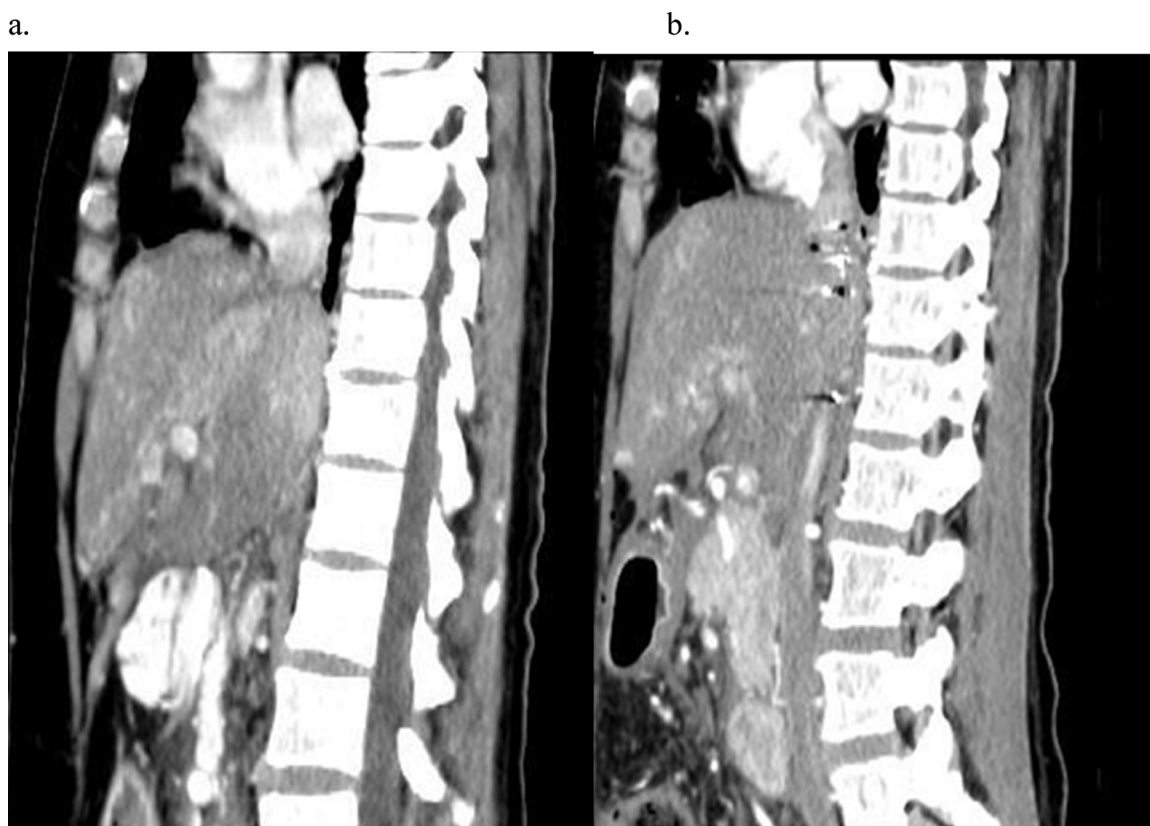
Sagittal Computed tomography (CT) showing absence of flow in the hepatic veins before (a) and after (b) IVC stent placement.
